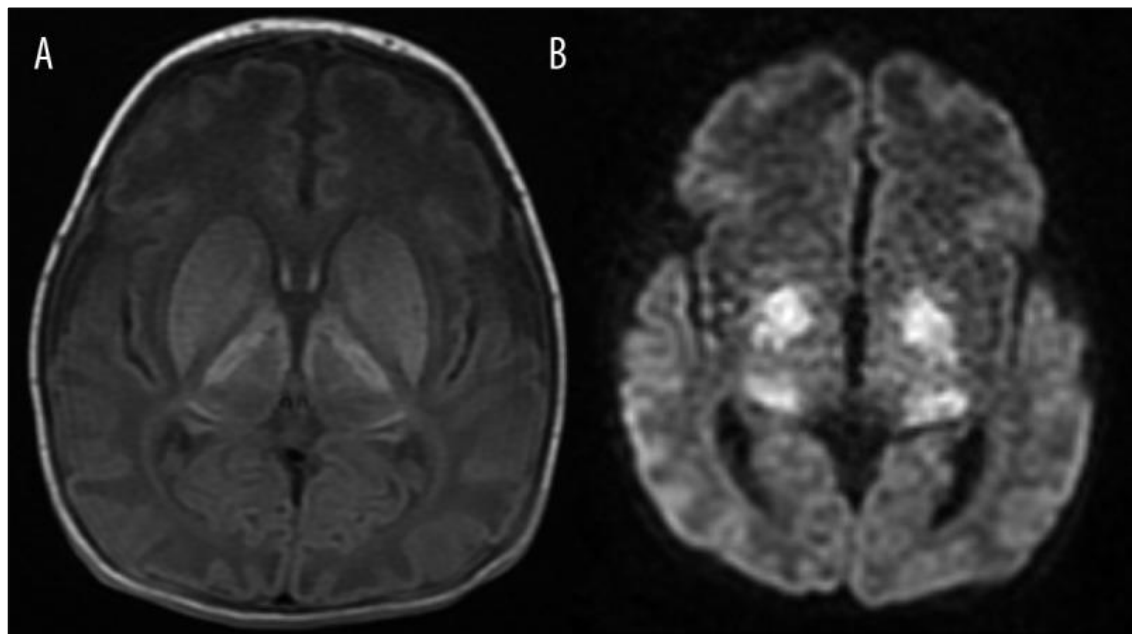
Acute asphyxia in MRI (Astra et al., 2012).
